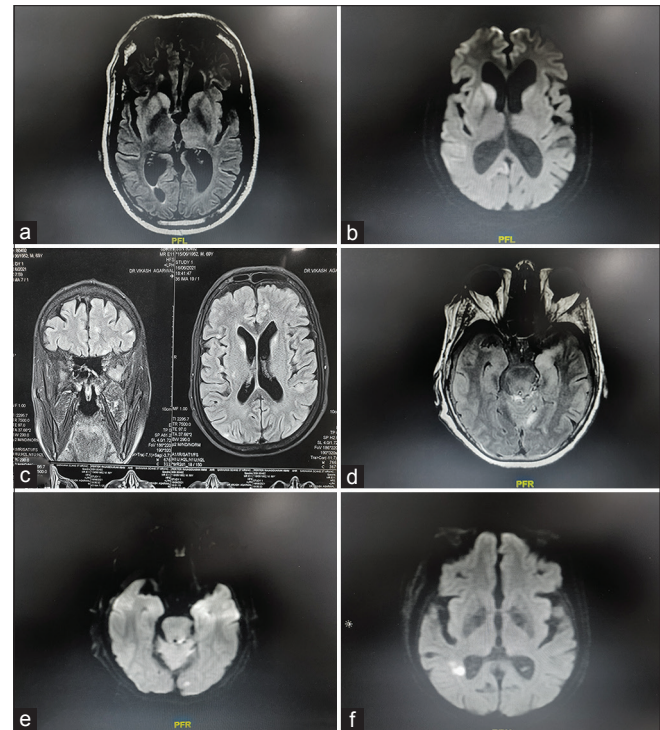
MRI Brain Changes showing specific areas of involvement
